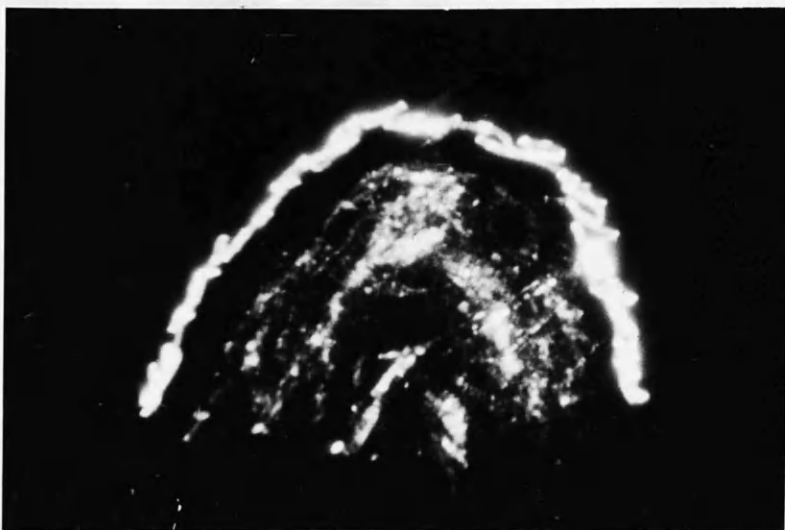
SCAN OF POSTERIOR ASPECT OF NECK.
